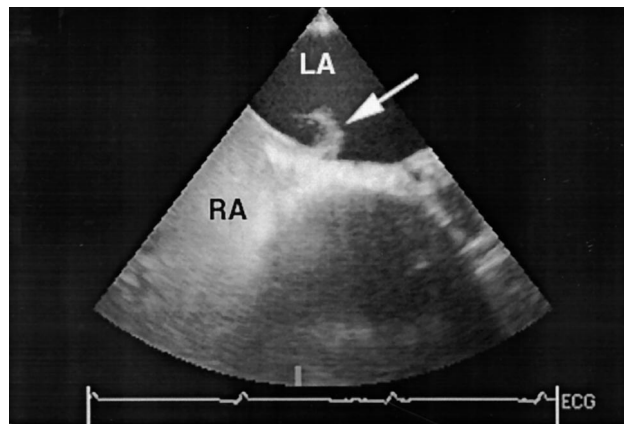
Contrast echocardiographic examination. Contrast material completely fills the right atrium and appears in the left atrium through a patent foramen ovale (arrow). RA indicates right atrium; LA, left atrium.
